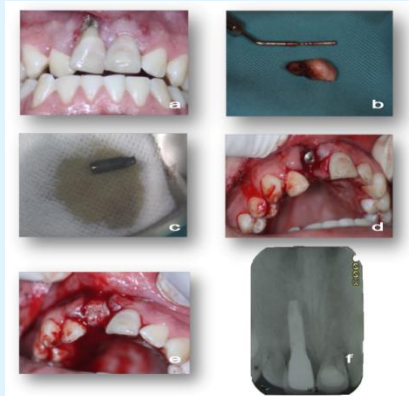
a) Central incisor lesion with apical decay and receding gum. b) Surgical access to proceed the central incisor extraction. c) PRF procedure where performed and dental implant was treated with PRF supernatant. d) Bone drilling was performing and was placed the treated dental implant. e) PRF autologous barrier was done and was placed into the alveolar socket protecting the dental implant. f) Sixty-days after surgery was performed the rehabilitation with ceramic crown and periapical radiography was taken suggesting the osseointegration.
